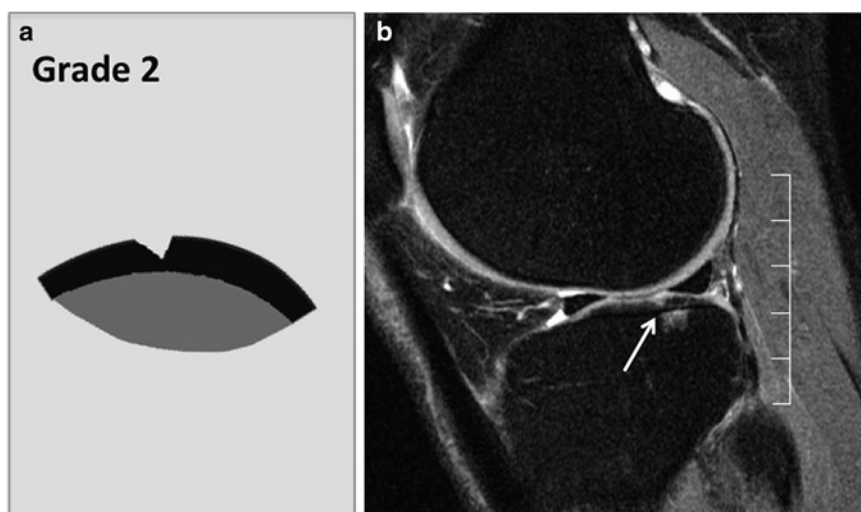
Whole-Organ-MRI-Score (WORMS) grade 2 lesion.*
